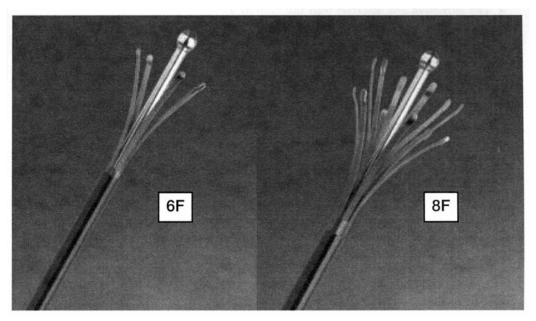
Two catheter sizes currently available, 6 French (left) and 8 French (right). Both contain a central lumen to allow through-the-catheter .025["] guide wires to assist ultrasound guidance for proper catheter positioning. (Photo courtesy of VNUS Medical Technologies, Inc., San Jose, CA, reproduced with permission).
